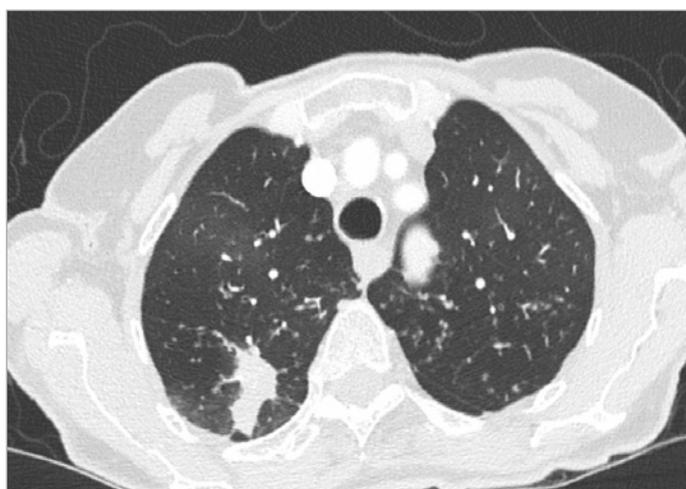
Second CT (after 7 months).
